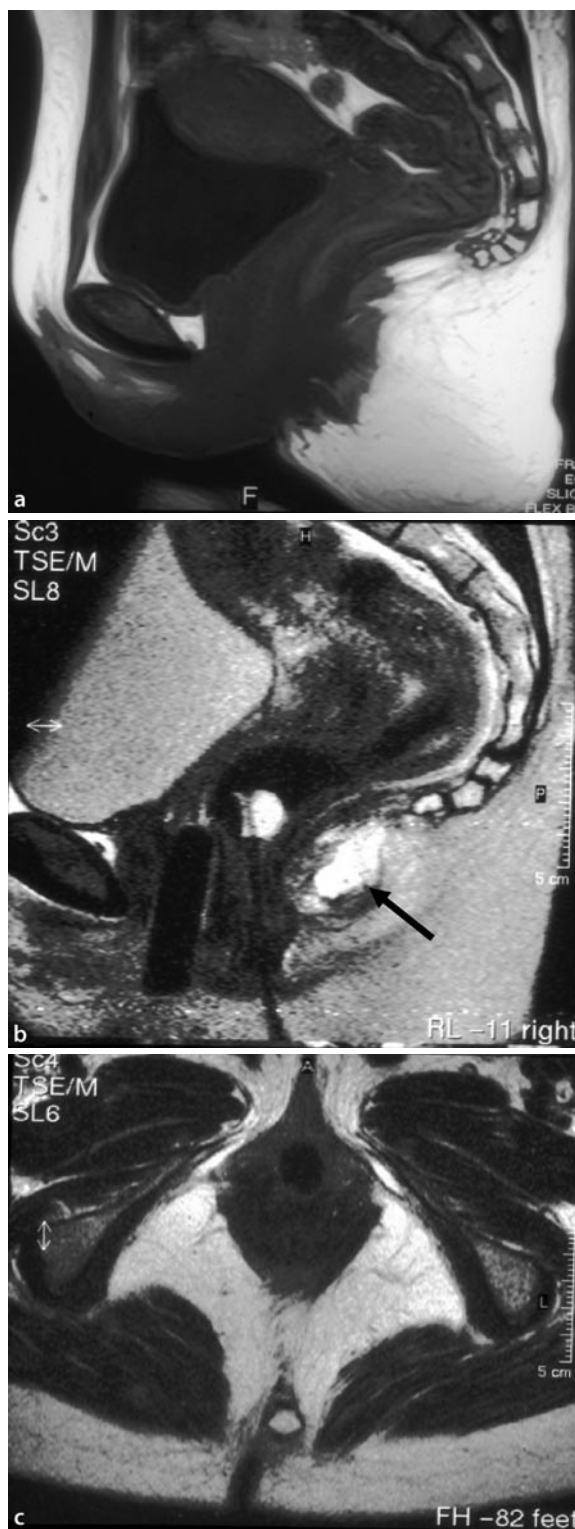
Sphincter dysplasia (MRI). a Normal, with corpus anococcygeum. b, c Corpus anococcygeum inserts in subcutis (arrow)
